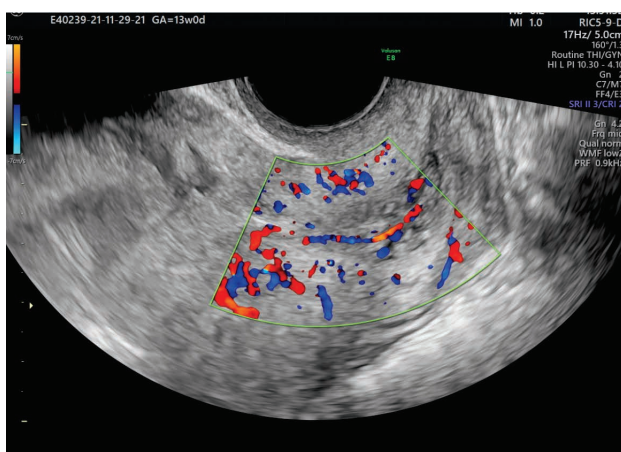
Transvaginal 2D ultrasound image of the cervix containing a mobile hyperechoic lesion. The color Doppler reveals the implantation site that is at the level of internal os (personal collection of Roxana Bohîlțea)
